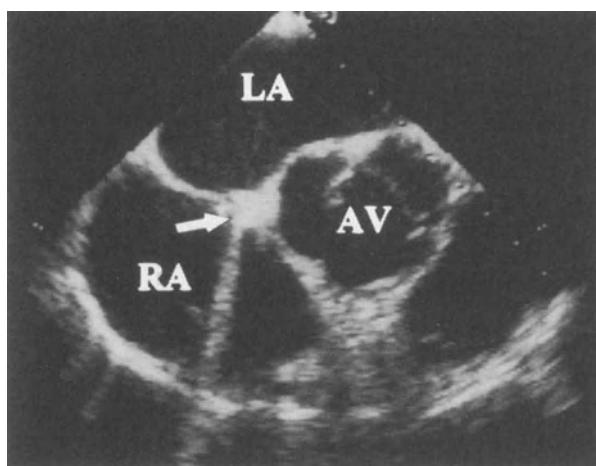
Transoesophageal echocardiographic images in the horizontal plane (left panel) and longitudinal plane (right panel) showing the position of the pacemaker tip in the interatrial septum (arrows). The tip of the pacemaker is at the most anterior portion of the interatrial septum, close to the aortic root. AV, aortic valve; LA, left atrium; RA, right atrium; SVC, superior vena cava.
